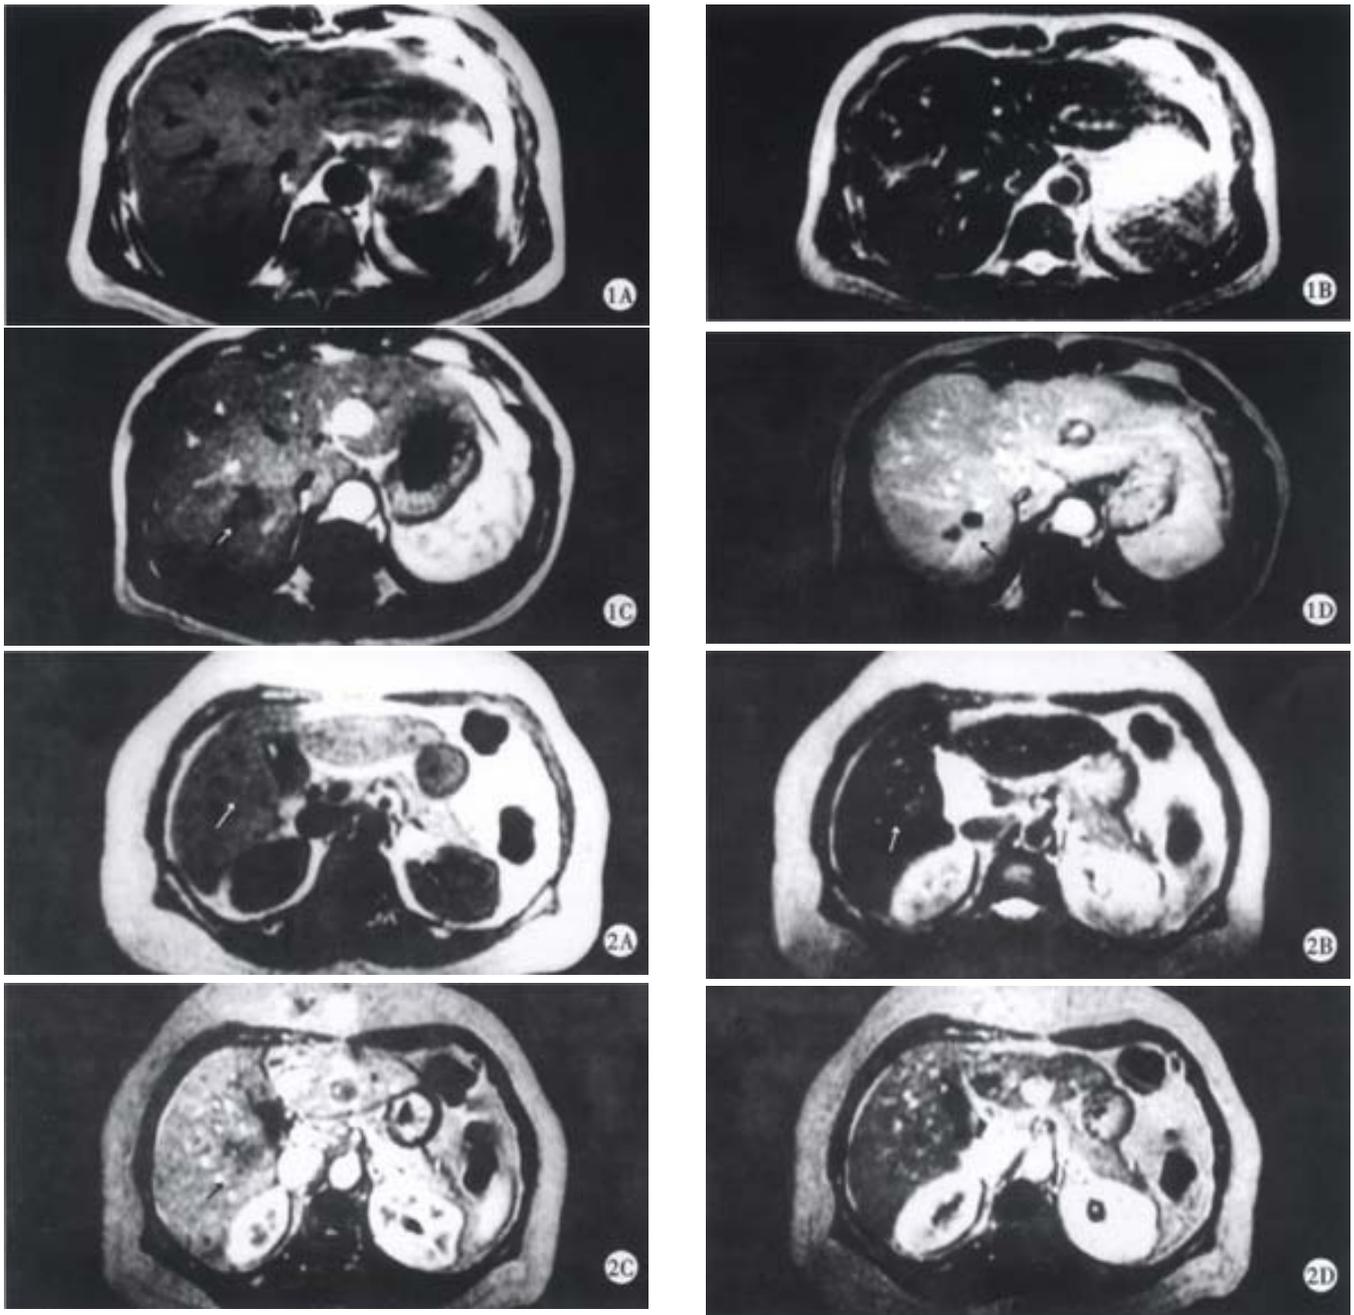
Inflammatory pseudotumor of the liver in the right posterior lobe. A SE T₁WI and B SE T₂WI could not show any lesions. C A hypointense lesion could be found in the right lobe (arrow), there is no enhancement in early arterial phase of dynamic contrast MRI. D portal venous phase of dynamic contrast MRI showed the enhanced septum (arrow).
